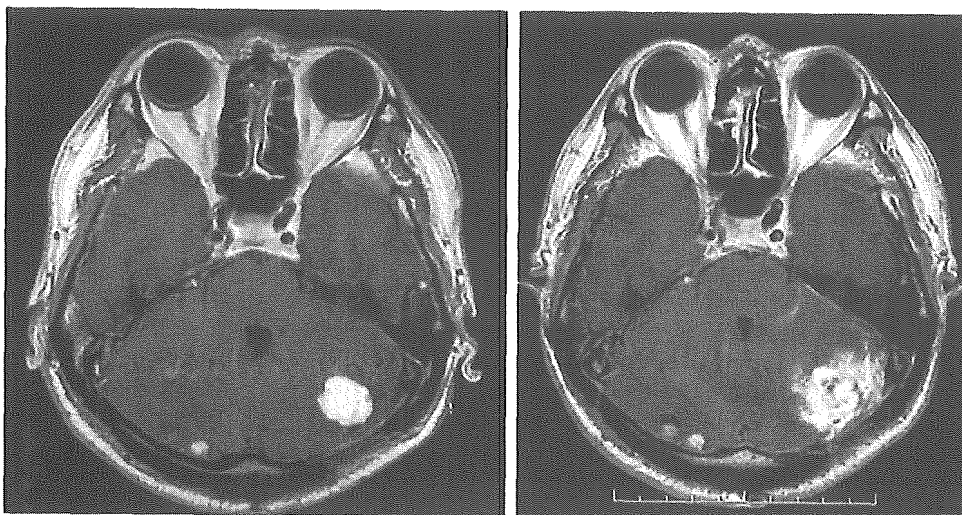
Magnetic resonance images obtained in a man who underwent a second GKS for two hemangioblastomas in the left cerebellar hemisphere (another lesion is not shown) (*left*). Two months later, abnormal peritumoral enhancement accompanied by brain edema was recognized, and 2 months later (4 months after GKS), the enhancement enlarged (*right*).
